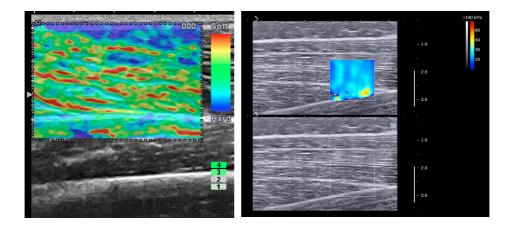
Elastography by ultrasound imaging. (A) Quasi-static elastography; (B) shear wave elastography.
